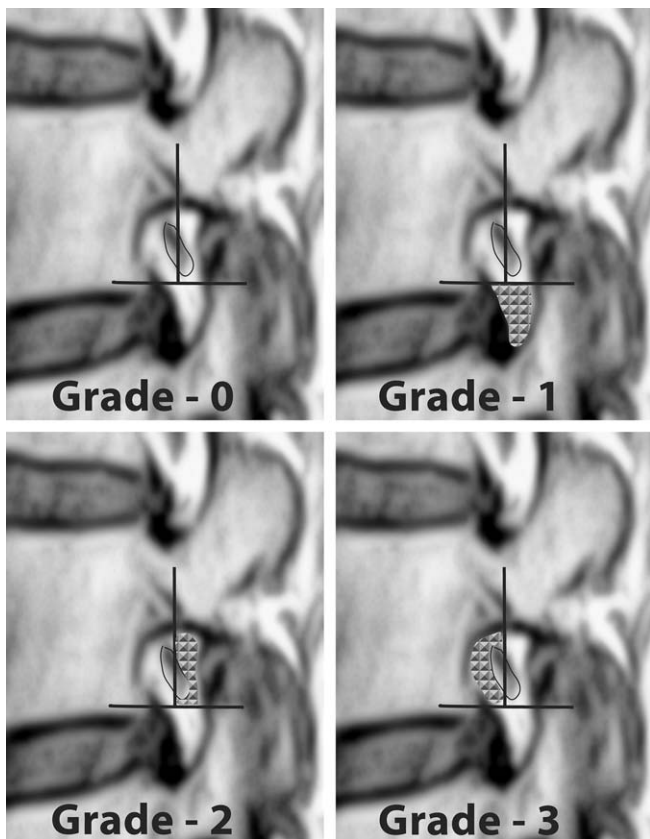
New classification system for grading foraminal stenosis, based on T1-weighted MRI. A, Grade 0; B, grade 1; C, grade 2; D, grade 3.
